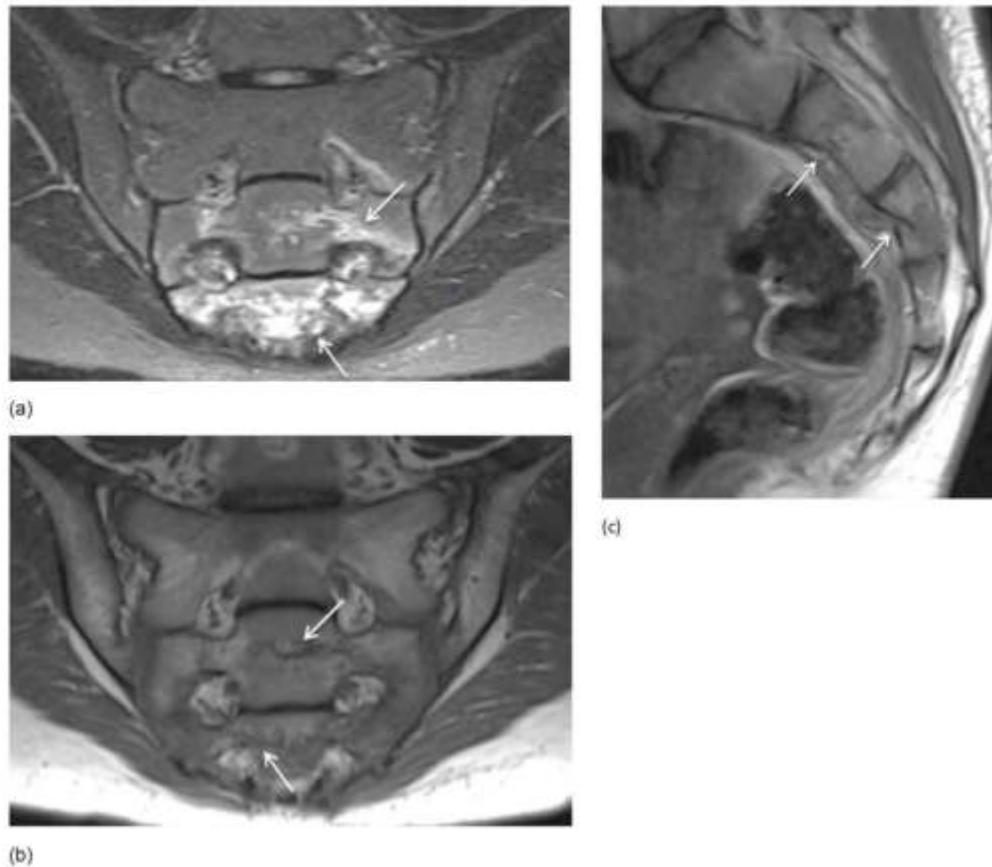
(a-b) Semicoronal STIR and T1 MR image in a 13-year-old girl with sacral fractures shows BME of S2-S3 on STIR (arrows) and transverse fracture lines on T1 (arrows). (c) Additional sagittal T1 was performed and shows disruption of the anterior cortex of S2 and S3 with mild anterior compression on S3 (arrows).
